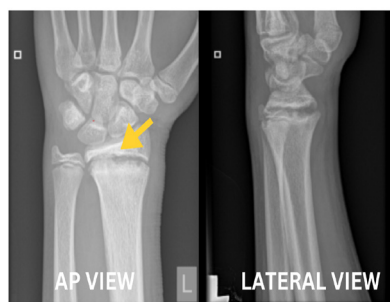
Xray of the wrist AP view (image on the left) showing fraying of the metaphyseal plate of distal radius (yellow arrow).
